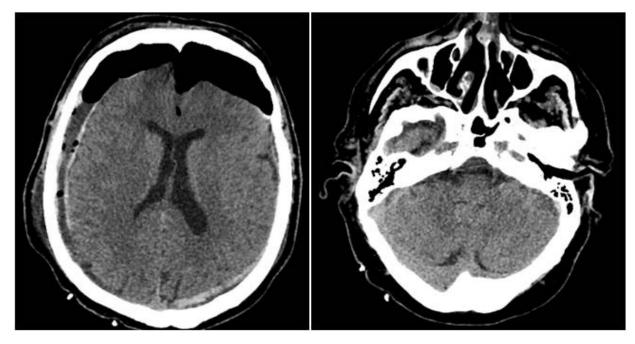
Axial and coronal non-contrast computed tomography scan of the brain after the fall of its height. Regression of chronic subdural hematomas with acute component at posterior frontal and parietal right. However, appearance of a large bilateral fronto-polar and fronto-orbital pneumcephalus (reaching in their largest diameter 23 mm) and some pneumocranium bubbles at the level of the Sylvian valleys of the two sides. No cerebellar abnormality was observed.
